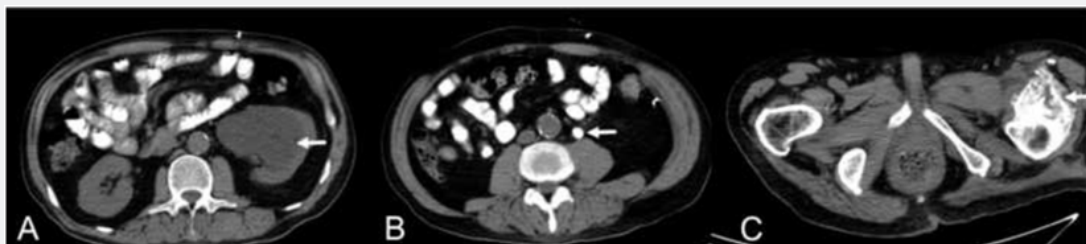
The abdominal CT images. A Marked hydronephrosis of the left kidney, B Calculus (size: 1.3 cm) impaction at left upper one-third of ureter, C Massive calcification at anterior aspect of left hip.
